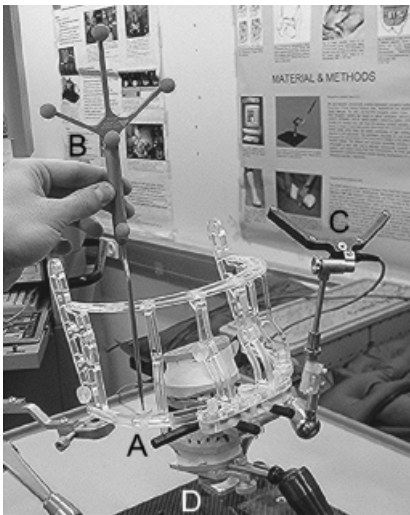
Image-to-physical (IP)-transformation of the dental stone cast to the corresponding computed tomography (CT) data by touching the markers on the SIP-Lab reference frame (marker 2 – A) with the navigation probe (B). The 'virtual' registration markers on the CT data are linked to the corresponding 'real' markers on the planning set-up. Thus, a navigation space around the dental stone cast was generated which allowed for navigation. The dynamic reference frame (C) which was rigidly mounted on a mechanical arm on the base plate (D) corrected for movements of the whole planning set-up with respect to the stereotactic camera of the navigation system.
